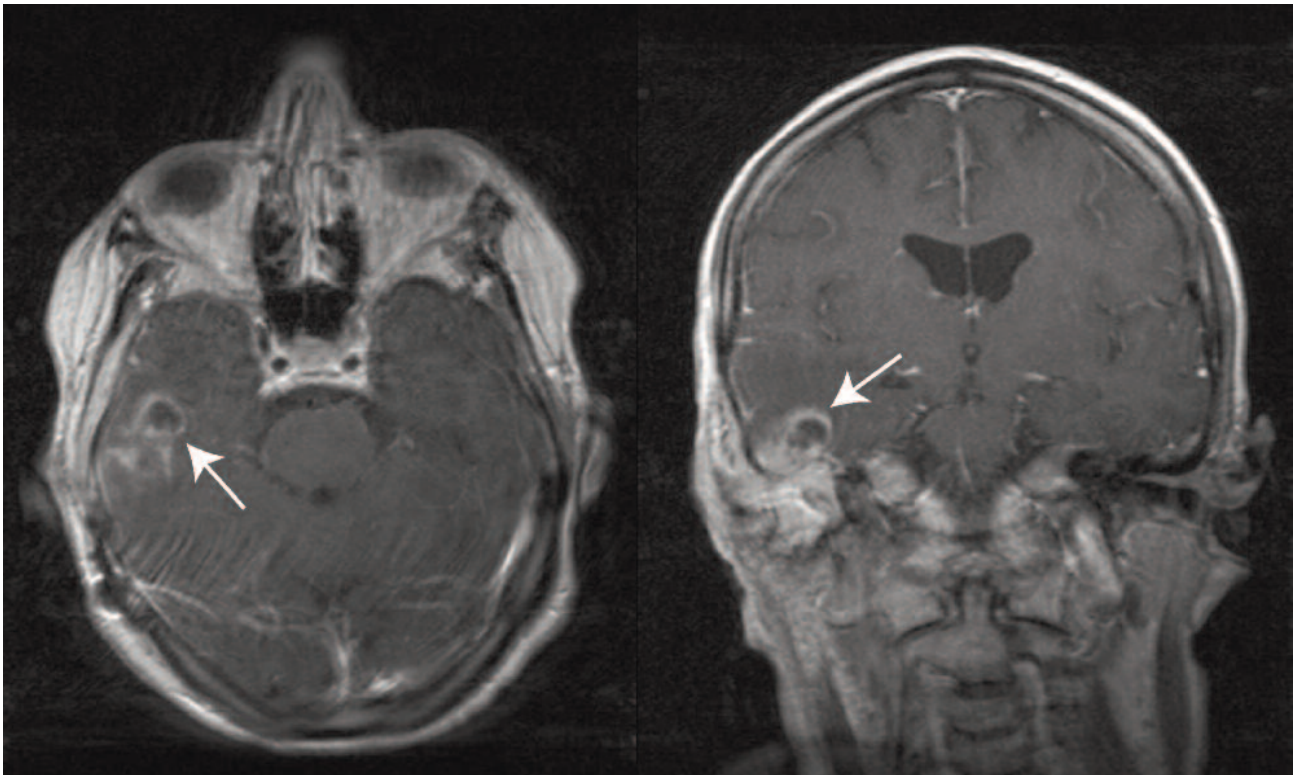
MRI scan (T1W + flowcomp, axial and coronal plane) was taken 5 days after the subtotal petrosectomy (January 2008). The arrows indicate the presence of an intracranial abscess.
